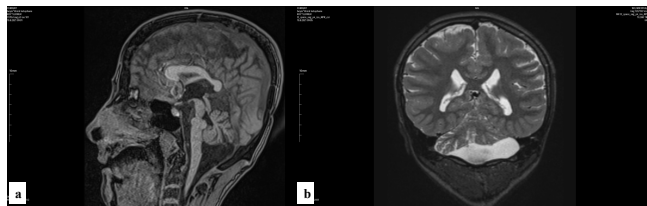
Cranial magnetic resonance imaging of patient 1 (a-Sagittal T1 sequence, b-coronal T2 sequence) shows dysplasia of corpus callosum, flattening of ventral pons, cerebellar atrophy, and cap-like structure protruding to fourth ventricle
